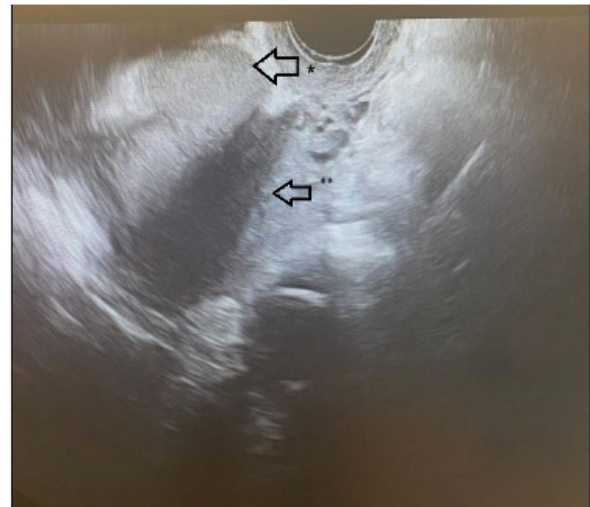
Preoperative ultrasonographic view of the abscess in the anterior uterine wall
